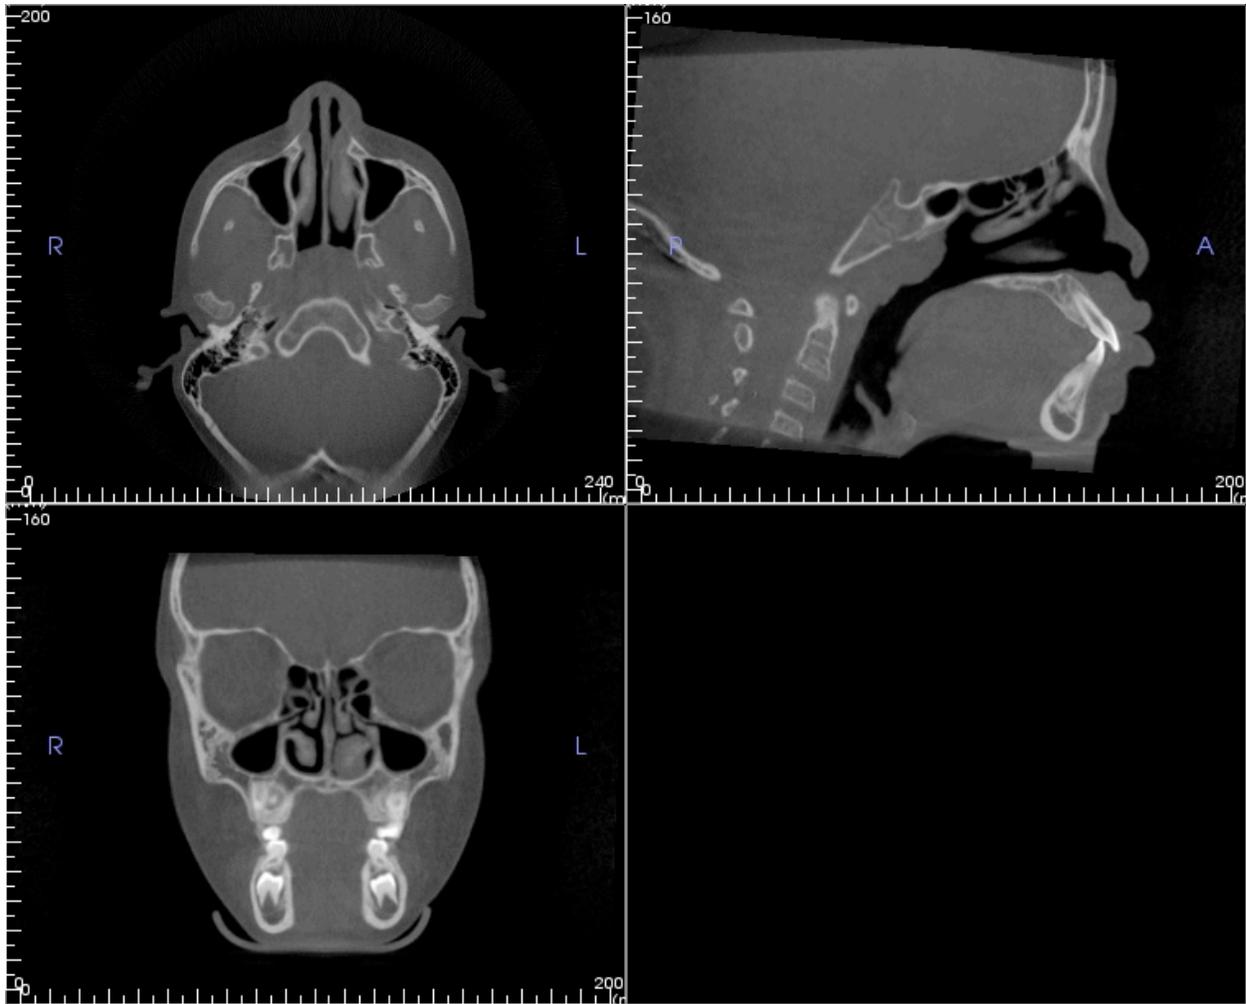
Reoriented CBCT image. The sagittal slice is oriented according to natural head orientation (NHO). The axial slice is oriented so the midpalatal suture is approximately perpendicular to the true horizontal. The coronal slice is oriented so a plane connecting the zygomaticofrontal sutures is approximately parallel to the true horizontal.
